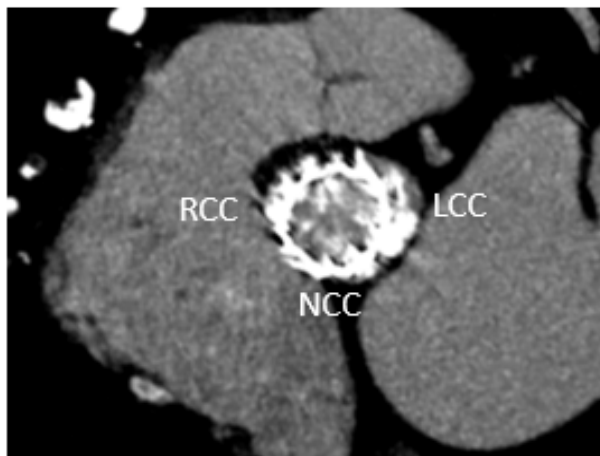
Pre-TAVI-in-TAVI Cardiac CT showed calcification of the three biologic prosthesis leaflets, with reduced mobility mainly of the right and left coronary cusps, with limited opening during ventricular systole (picture taken from systolic frame).
